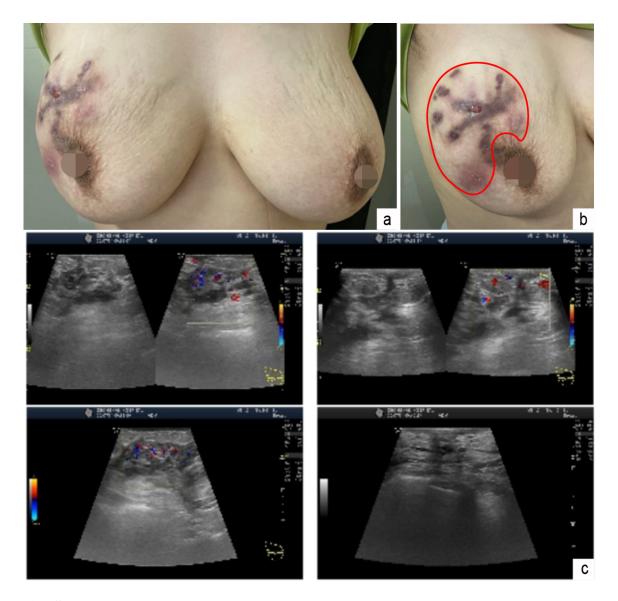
Complex refractory stage. a, b Granulomatous lobular mastitis in a 33-year-old woman with a palpable mass and persistent wound infection of 6 months' duration in the outer upper and lower quadrants of the right breast, with hyperaemia and swelling skin, without nipple retraction. c Abscesses (5.3 cm \times 0.6 cm), sinus, fistula, skin ulceration and pus were detected by ultrasound
